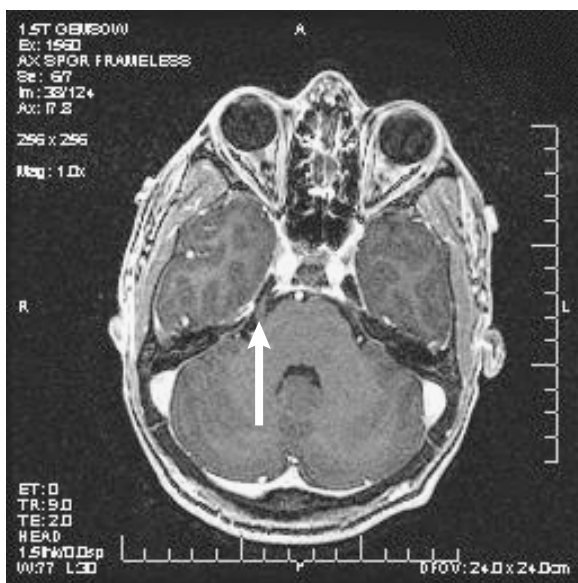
Fifth nerve as it travels toward Meckel's cave, as seen on magnetic resonance imaging.
